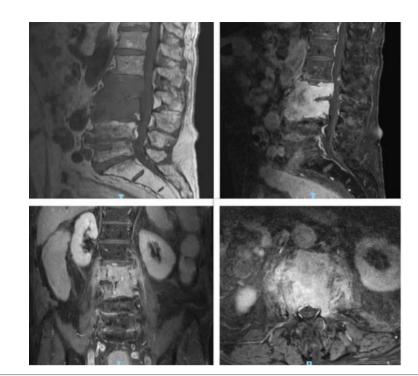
MRI scan of the lumbar spine performed at a different hospital when the diagnosis of osteolytic lesion at L2-L3 level was first established. After the MRI, a CT-guided biopsy was performed which was non diagnostic.
